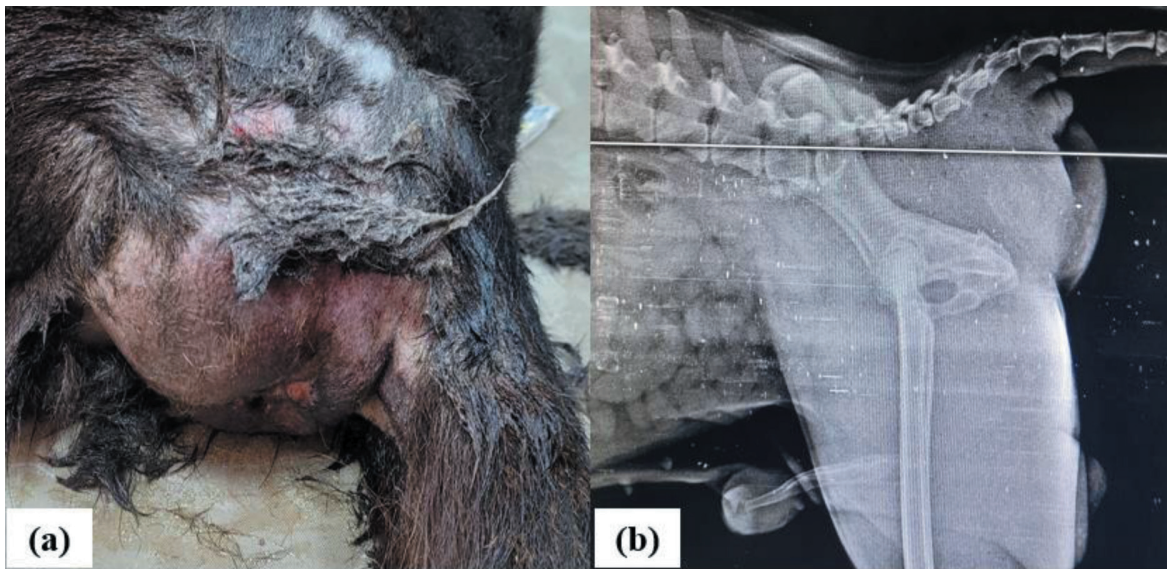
(a) Protruded mass on the left side of the anus. (b) Lateral abdominal radiograph revealed soft tissue opacity in the protruded mass and absence of bladder and prostate shadow in the caudal abdomen
